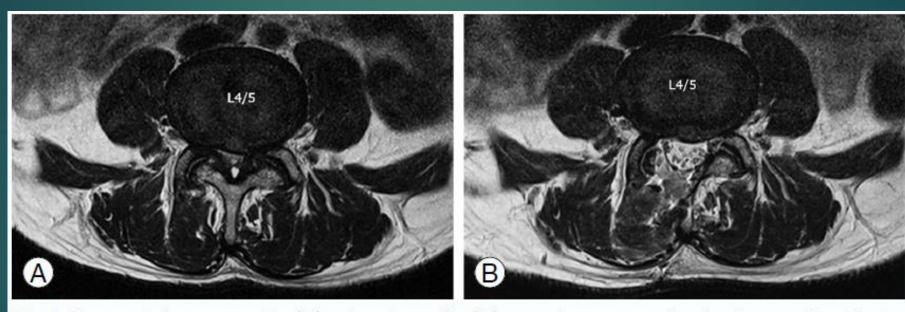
Representative preoperative (A) and postoperative (B) magnetic resonance imaging images of a patient.
